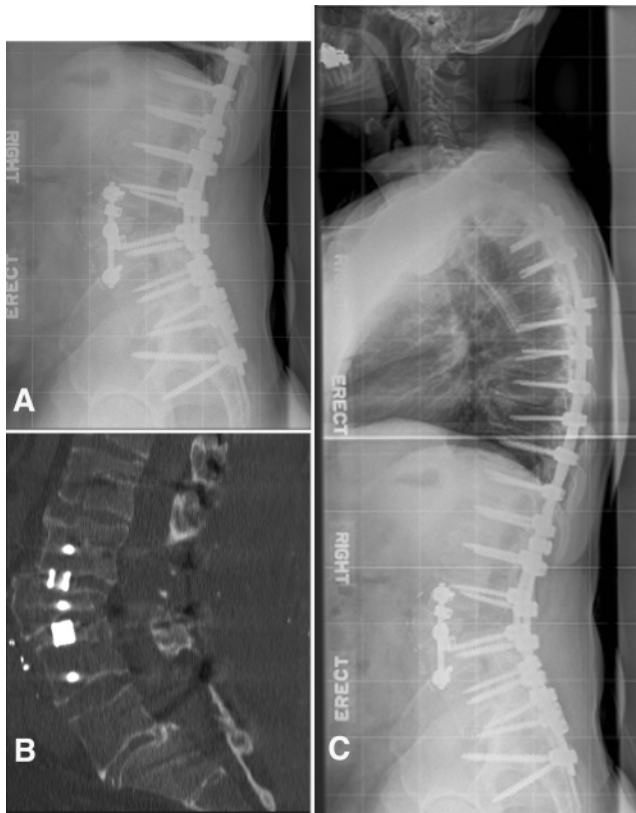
Postoperative lateral radiograph (A), sagittal reconstruction CT (B), and lateral 36-inch scoliosis radiograph (C) after anterior/posterior revision.
